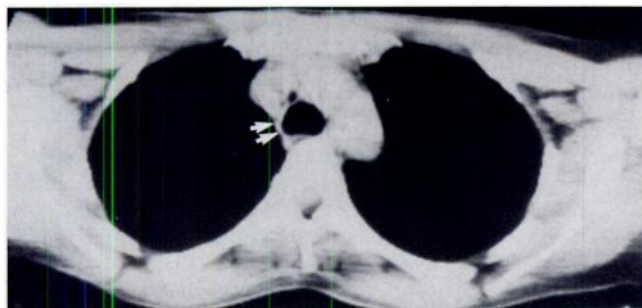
CT image just superior to level of right upper lobe bronchus. Right paratracheal tissue (arrows) was interpreted as azygos vein. At surgery, this area was involved by adenoid cystic carcinoma.
